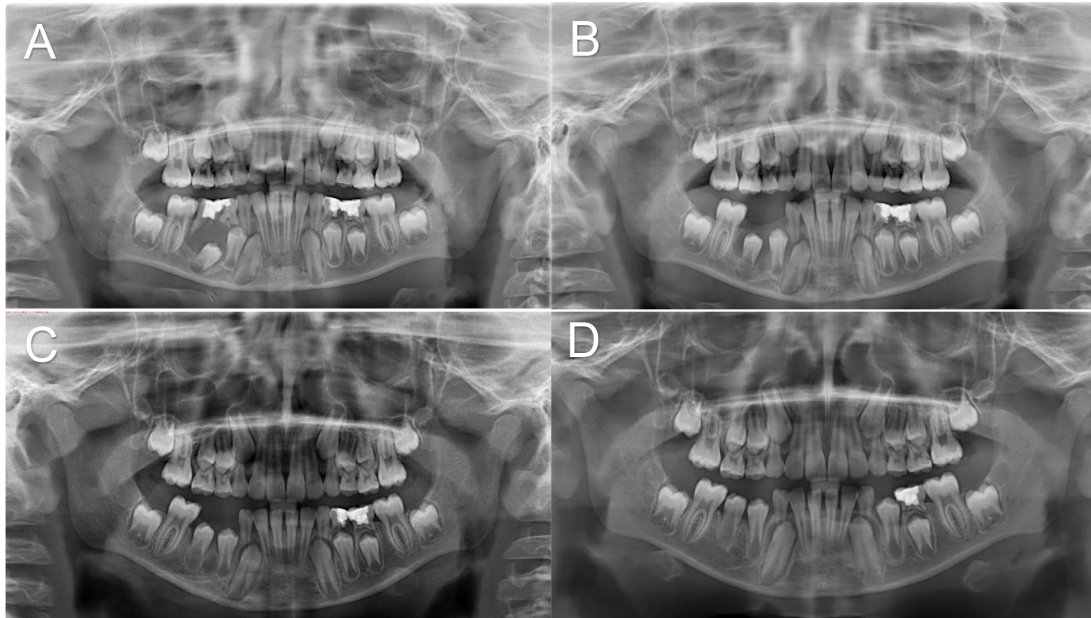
Case 4: panoramic radiographic findings during treatment. (A) Pre-operative. (B) Post-operative 3-month follow-up. (C) Post-operative 6-month follow-up. (D) Post-operative 12-month follow-up.
